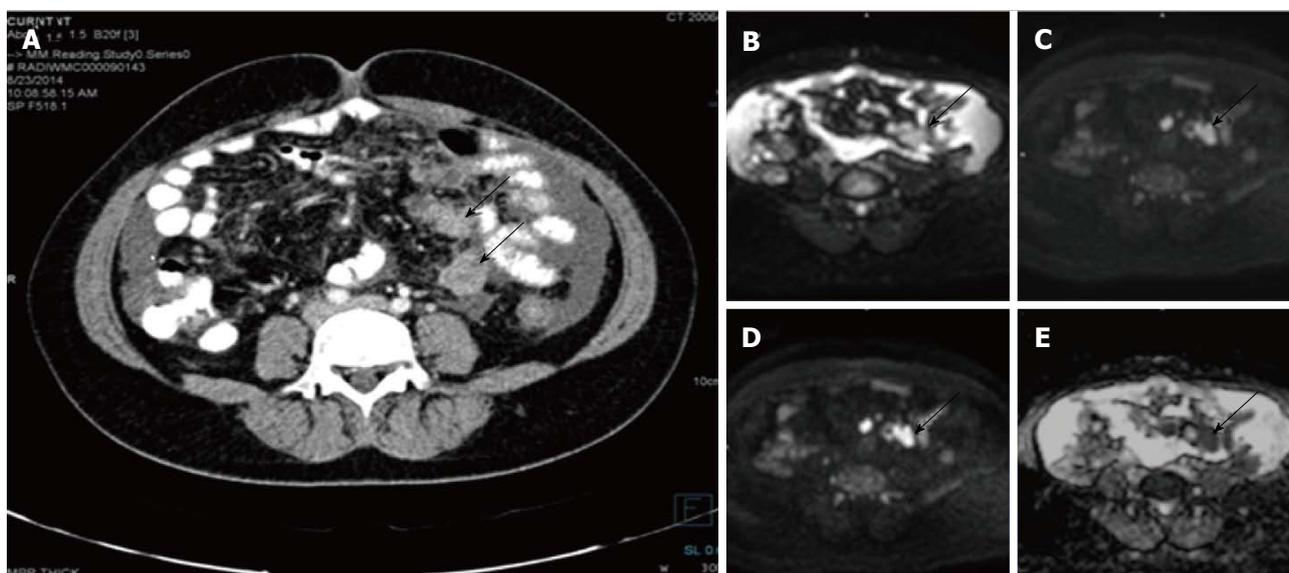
Serosal deposits in carcinoma ovary. Axial contrast enhanced computed tomography image (A) of a patient with known ovarian cancer shows enhancing soft tissues (arrows) over the surface of small bowel suggestive of serosal deposits. On diffusion weighted imaging, b 0 (B), b 400 (C), b 800 (D) and ADC (E) images show significant diffusion restriction in the serosal deposits. These lesions were proven to be malignant deposits on fine needle aspiration cytology. ADC: Apparent
